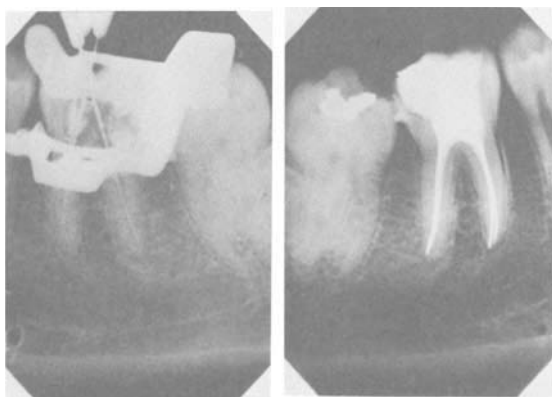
(a) Non-vital  $\overline{7}$  immediately after root filling with silver cones and AH 26. (b) One year after root-filling. Note the absence of periapical change.
